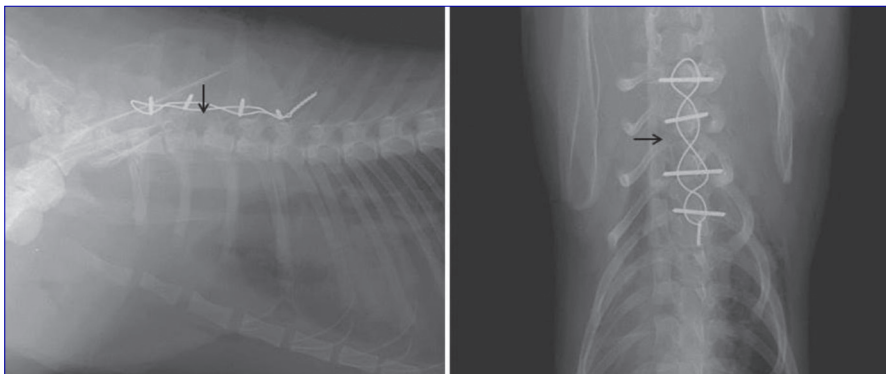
These views present repositioning of the intervertebral space (arrows) and vertebral column in the lateral and ventrodorsal radiographs
